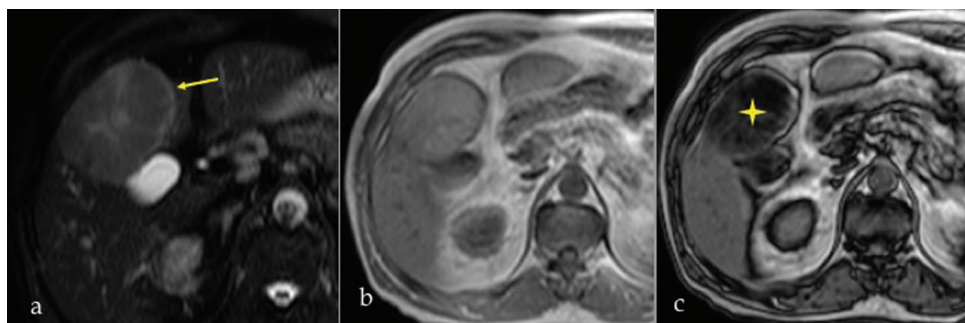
Hepatocellular adenoma on magnetic resonance imaging. a. T2W shows a mass with a T2 hyperintense rim giving atoll sign (arrow), (b) in phase and (c) out of phase images show out of phase signal drop (star) indicating abundant fat.
